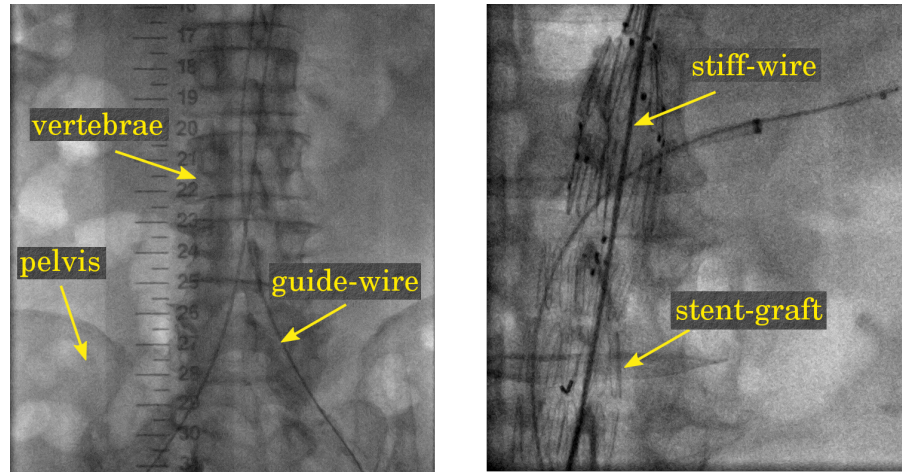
Example standard screening images using low dose X-ray. The real-time 2D images clearly show high contrast structures such as the interventional instruments and bony anatomy, but not vasculature.
